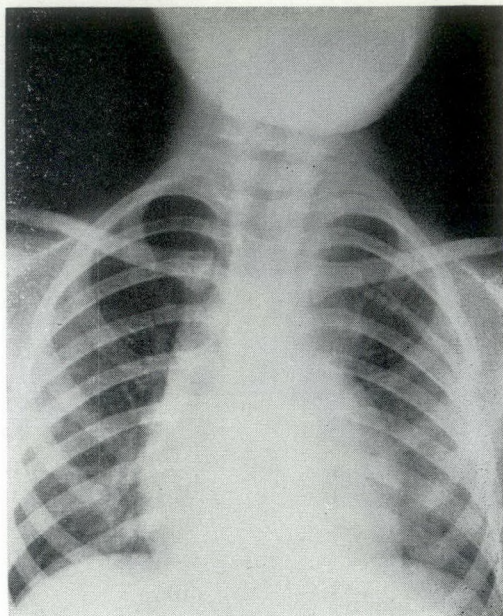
Miss M.N. Radiograph of chest taken two and one-half years after removal of extensive cystic hygroma of left side of neck and upper zone of left thoracic cavity.
